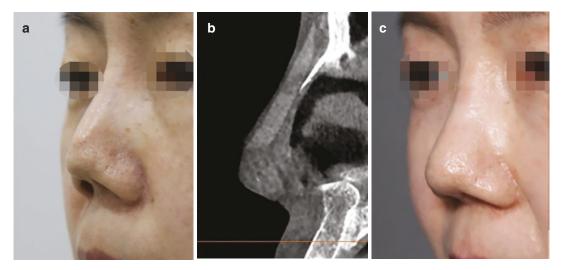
Supratip demarcation was shown due to caudally thick implant. (a) Preoperative view, (b) preoperative CT scan, and (c) postoperative view
